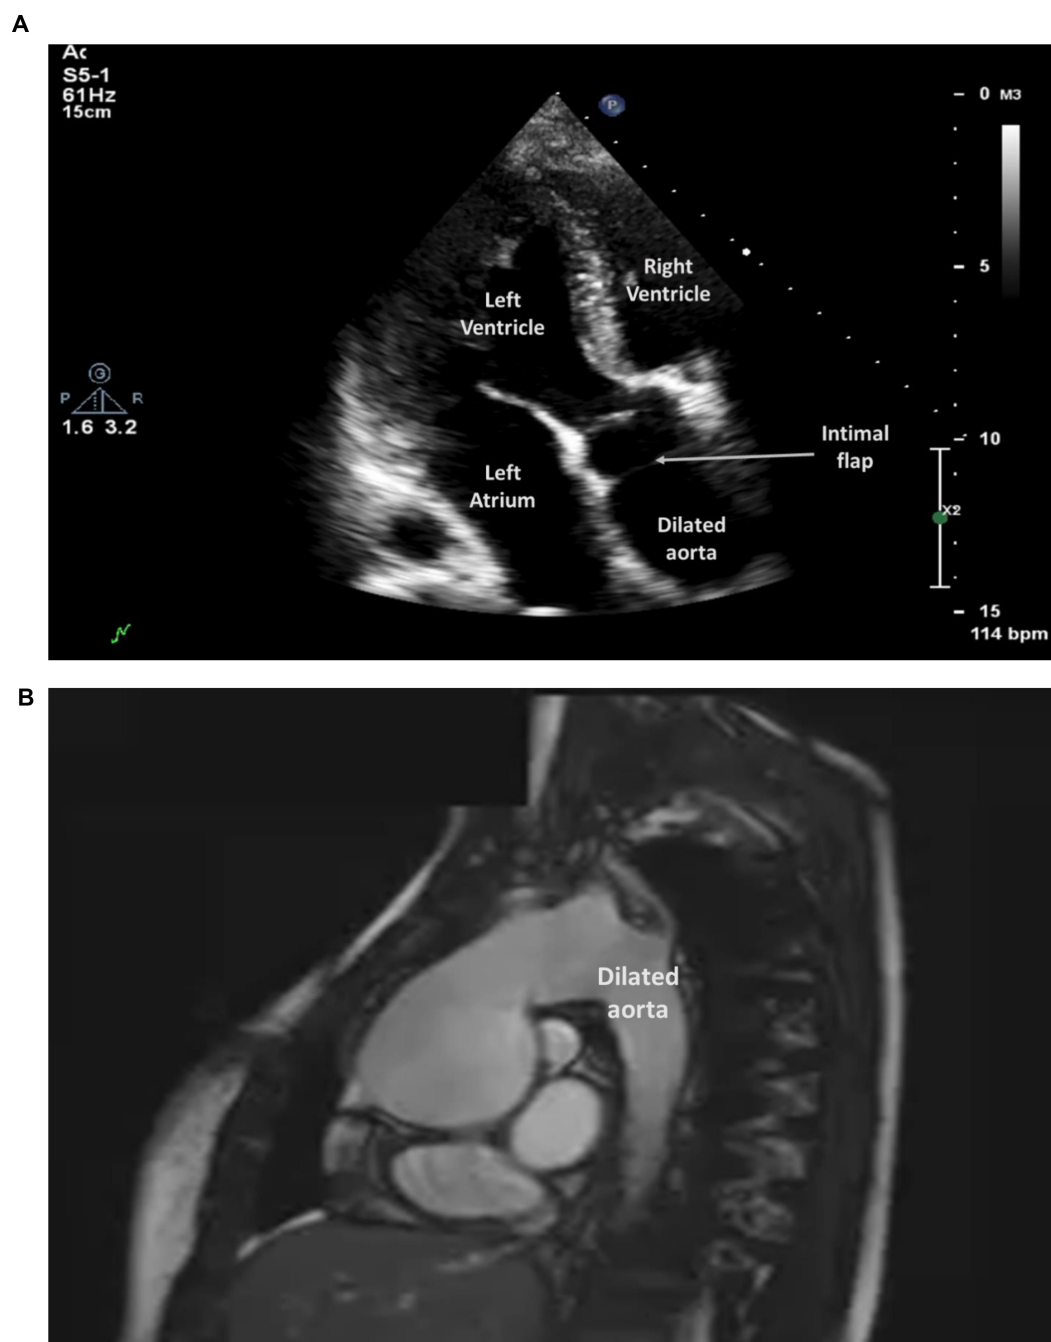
Different imaging modalities of thoracic aortic pathology in Case 2. (A) Apical three chamber view of transthoracic echocardiography showing the chronic aortic dissection and dilated aorta. The white arrow signifies the intimal flap arising from the aortic dissection. (B) shows a cardiovascular magnetic resonance sagittal view of the enlarged ascending aorta.
